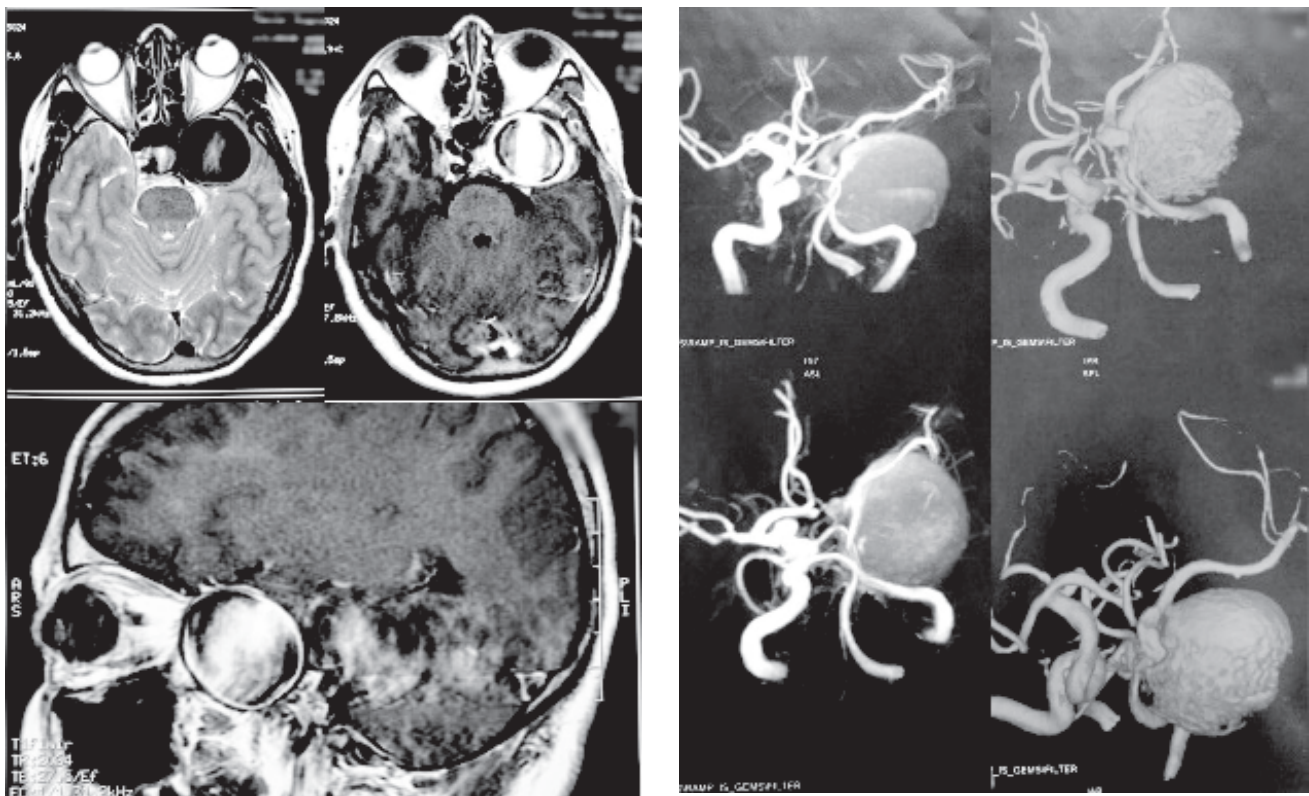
A) Nine diagnostic gazes showing left gaze palsy. B) Color fundus photograph showing infero-temporal BRVO with macular edema in right eye. C) OCT Macula showing macular edema. D) MRI brain showing left sided Internal Carotid Artery aneurysm. E) MRA showing aneurysm of internal carotid artery.
